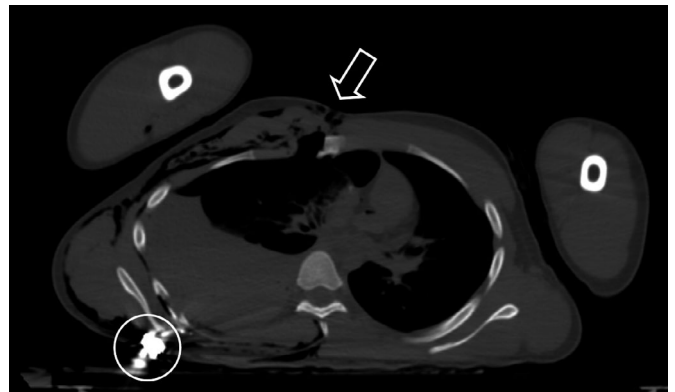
Postmortem computed tomography (PMCT) horizontal view of the thoracic cavity showing an entrance wound (arrow) on the anterior side of the chest and a retained bullet in the posterior chest wall (circle).
